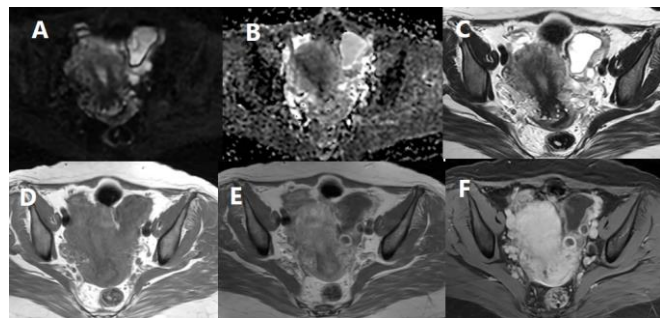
(A) DWI, (B) ADC map, (C) Axial T2, (D) Axial T1 pre-contrast, (E) Axial T1 post-contrast WIs, (F) Axial fat sat T1 post-contrast show left ovarian multi-loculated thickened wall cystic lesion displays DWI high signal in (A) ADC map mild low signal in (B), thickened irregular wall with T2 WI internal bright signal (C) T1WI low signal (D), marginal uniform post-contrast
